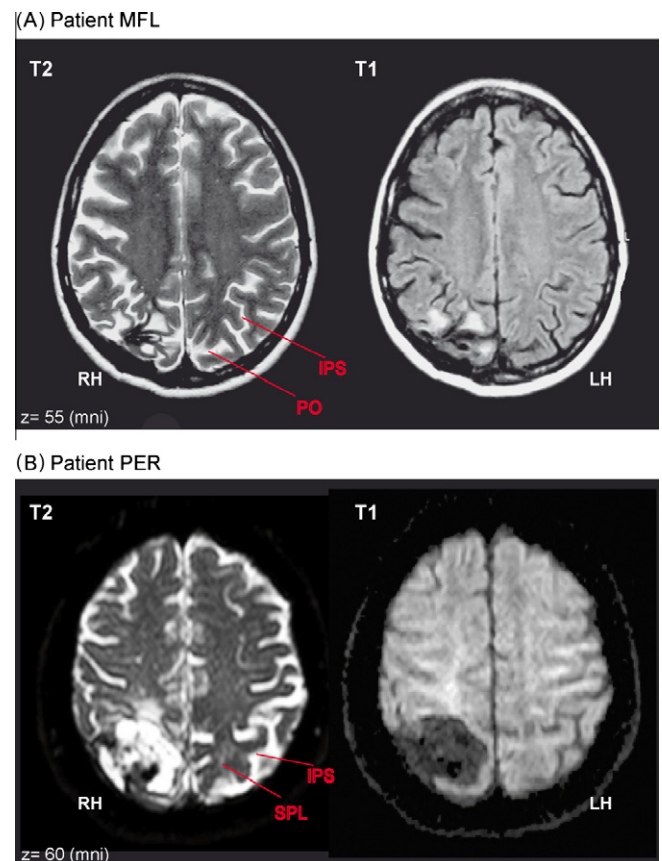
MRI slices showing lesions of patient MFL (A) and patient PER (B) under T1 (left) and T2 (right) contrasts. For both patients, the lesions include the parieto-occipital junction (PO), the superior parietal lobule (SPL) and the posterior part of the intra-parietal sulcus (IPS).
